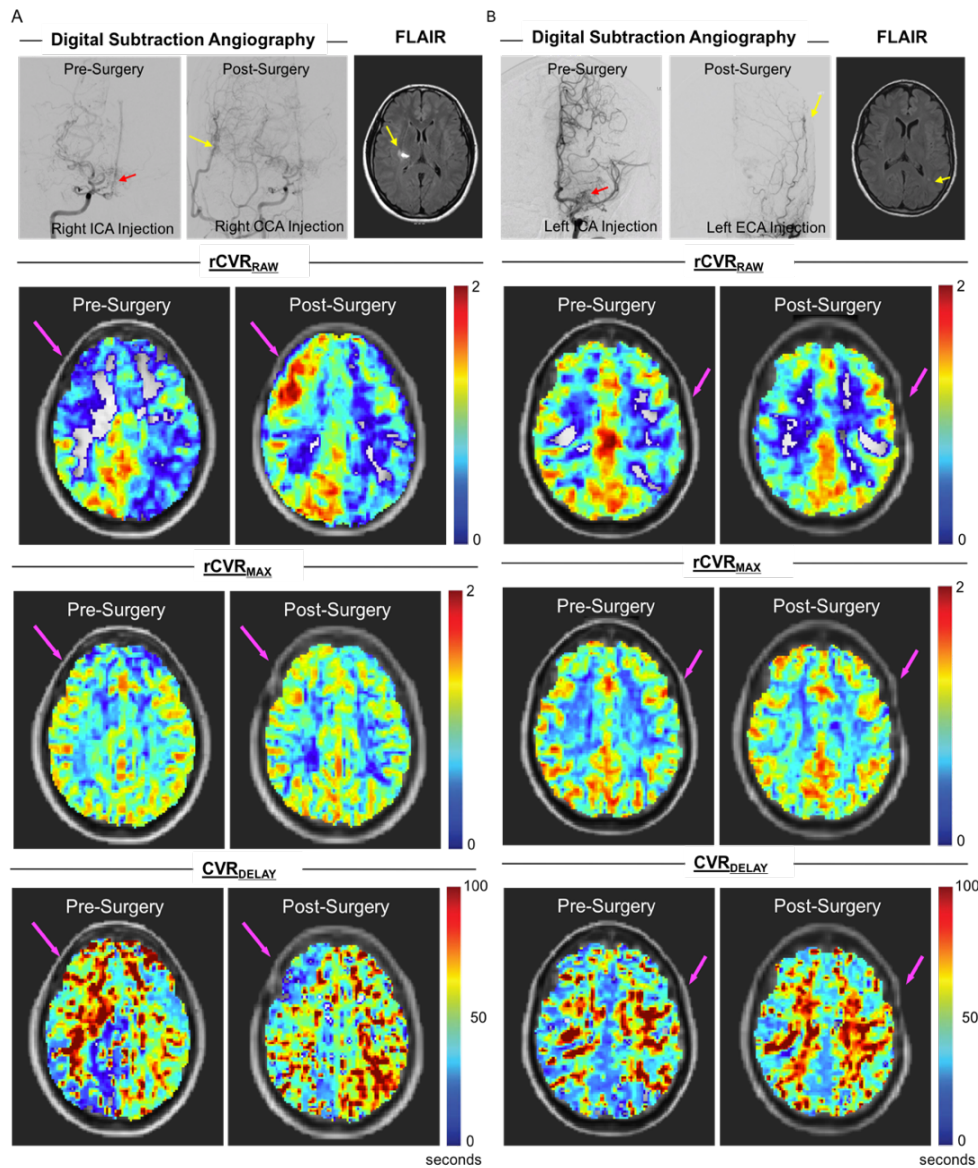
DSA and vascular compliance imaging pre-and post-revascularization. (A) A participant with robust post-surgical revascularization of the right middle cerebral artery (MCA) territory; shown are anterior-posterior projections of internal carotid artery (ICA), common carotid artery (CCA) and external carotid artery (ECA) injections. The red arrow denotes moyamoya collaterals in the pre-surgical image, and the yellow arrow shows the region of neovascularization. This patient presented with an infarct in the right hemisphere resulting in a hyperintense signal on FLAIR. Additional panels in (A) show correspondent BOLD-derived vascular compliance measures. Improvement (increase) in $rCVR_{RAW}$, modest improvement in $rCVR_{MAX}$, and improvement (decrease) in CVR_{DELAY} are observed post-surgery in the right hemisphere (magenta arrows denote operative hemisphere). In contrast, a participant with minimal post-surgical neovascularization following left-sided surgery is shown in (B). This patient presented with a left sided infarct which appears as a punctate FLAIR hyperintense lesion in the periventricular white matter. Corresponding BOLD-derived vascular compliance measures show decrease in left-sided $rCVR_{RAW}$, stable $rCVR_{MAX}$, and increase in CVR_{DELAY} .
